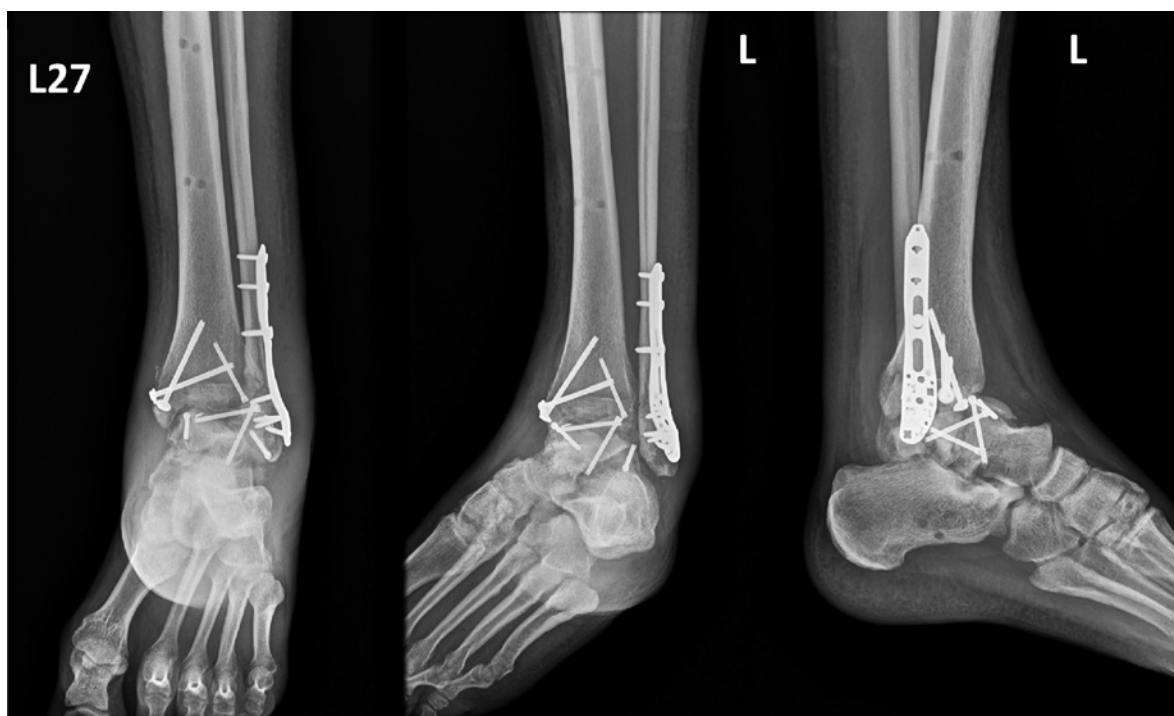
Postoperative radiographs of open reduction and internal fixation of the left tibia and distal fibula.
